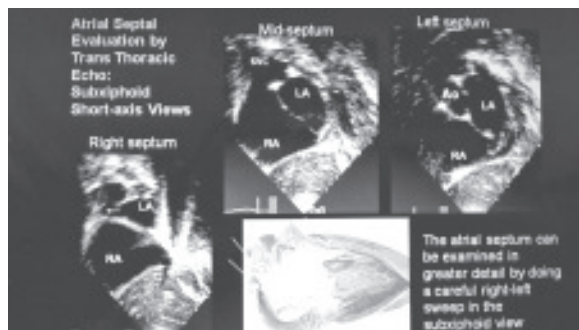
Atrial septal evaluation by 2D echo from subcostal views (MIOT e-Textbook of Echocardiography in congenital heart disease chapter:III)
